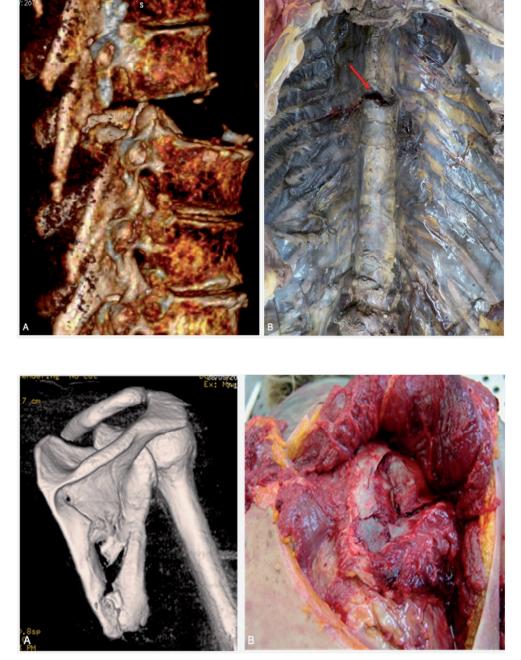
(A) 3D-VRT (Volume Rendering Technique) of the CT data and Autopsy examination (B): D7 anterolisthesis with bilateral isthmic lysis and loss of normal joint relations with D6.
